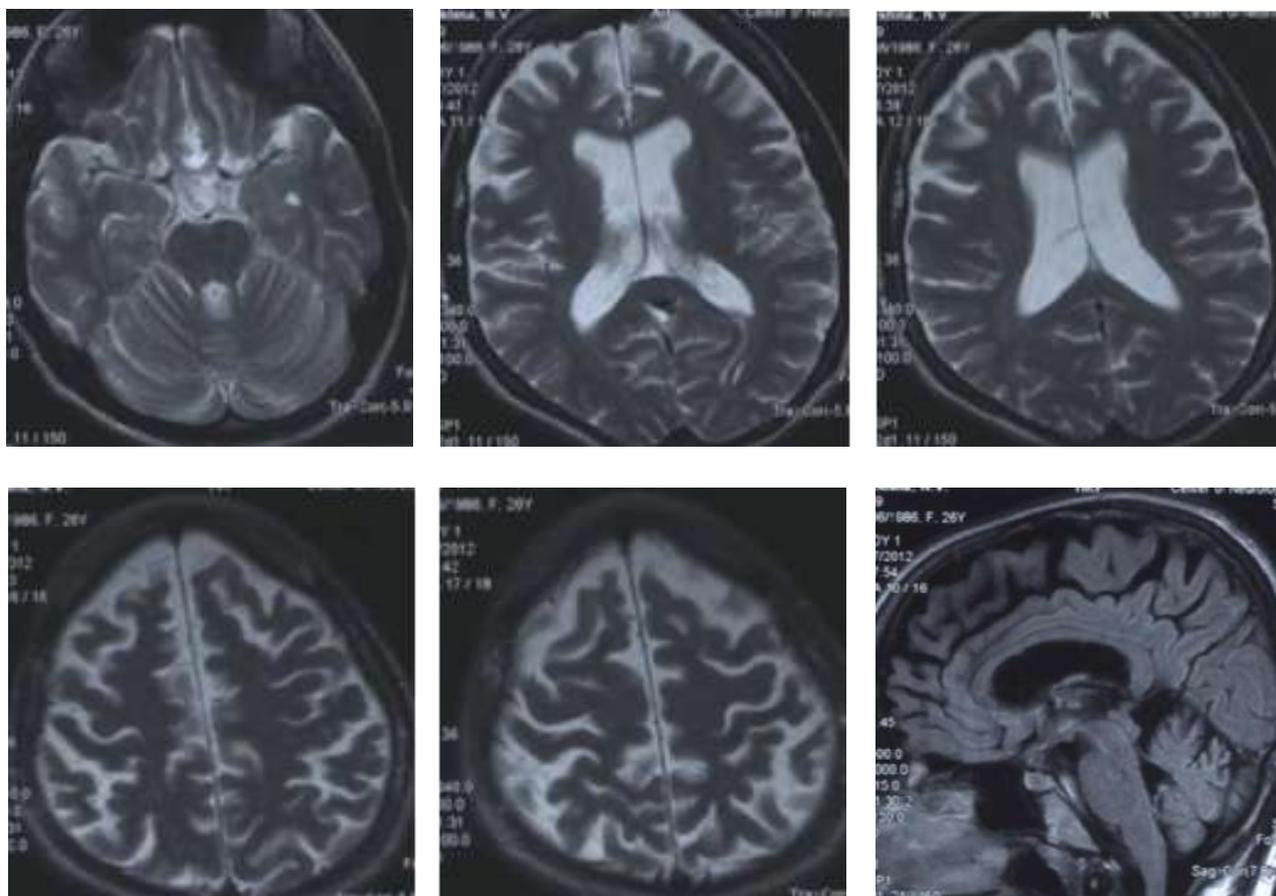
MRI. Diffuse brain atrophy in 21-year old NPC patient.
